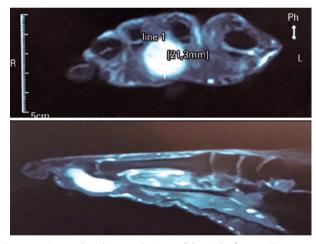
Sagittal and coronal views of the right foot on T2 magnetic resonance images showing hyperintense signal in the forefoot, with an increase in volume between the second and third toes. Source: Author's personal archive.
